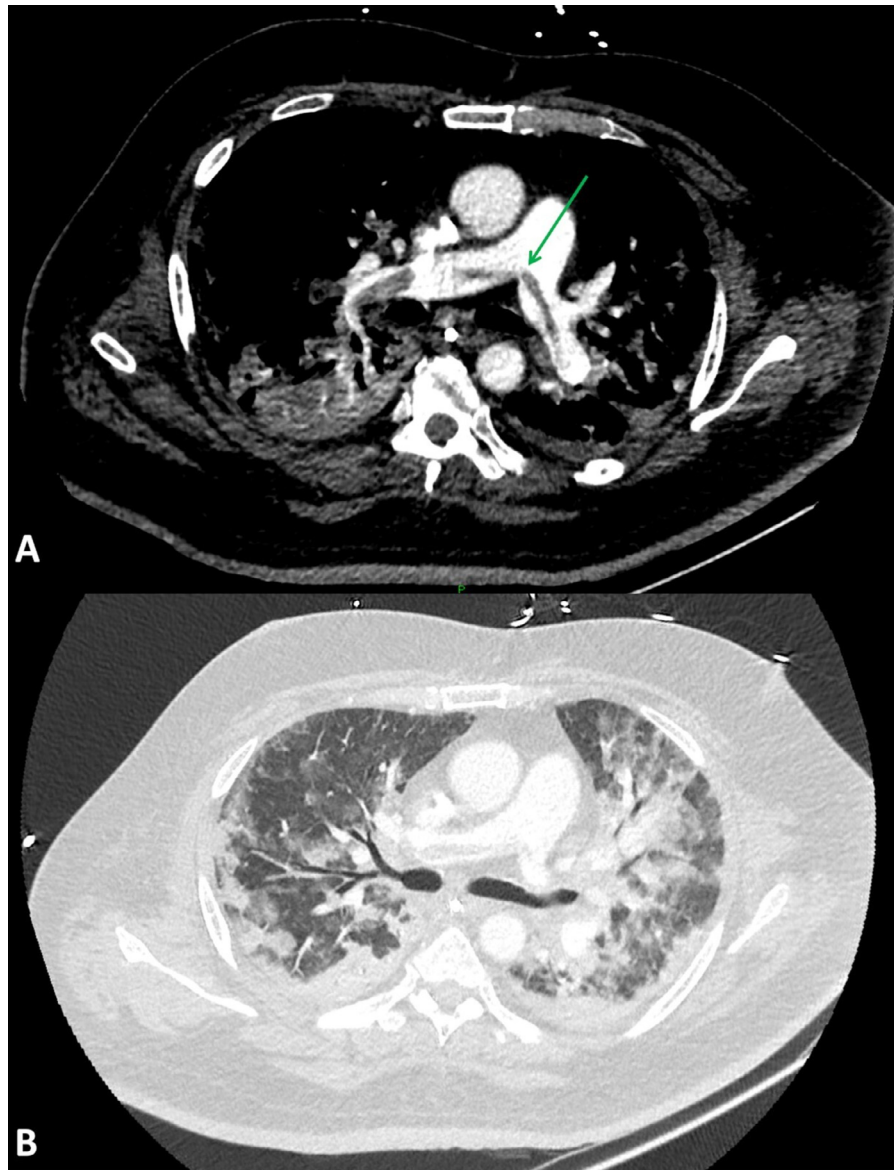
CT pulmonary angiogram. (A) Saddle pulmonary embolus (green arrow) with extension into the segmental and subsegmental pulmonary artery branches of the right and left hemithorax. (B) Extensive bilateral ground glass attenuation and patchy consolidation with a peripheral predominance, consistent with COVID-19 pneumonitis.
